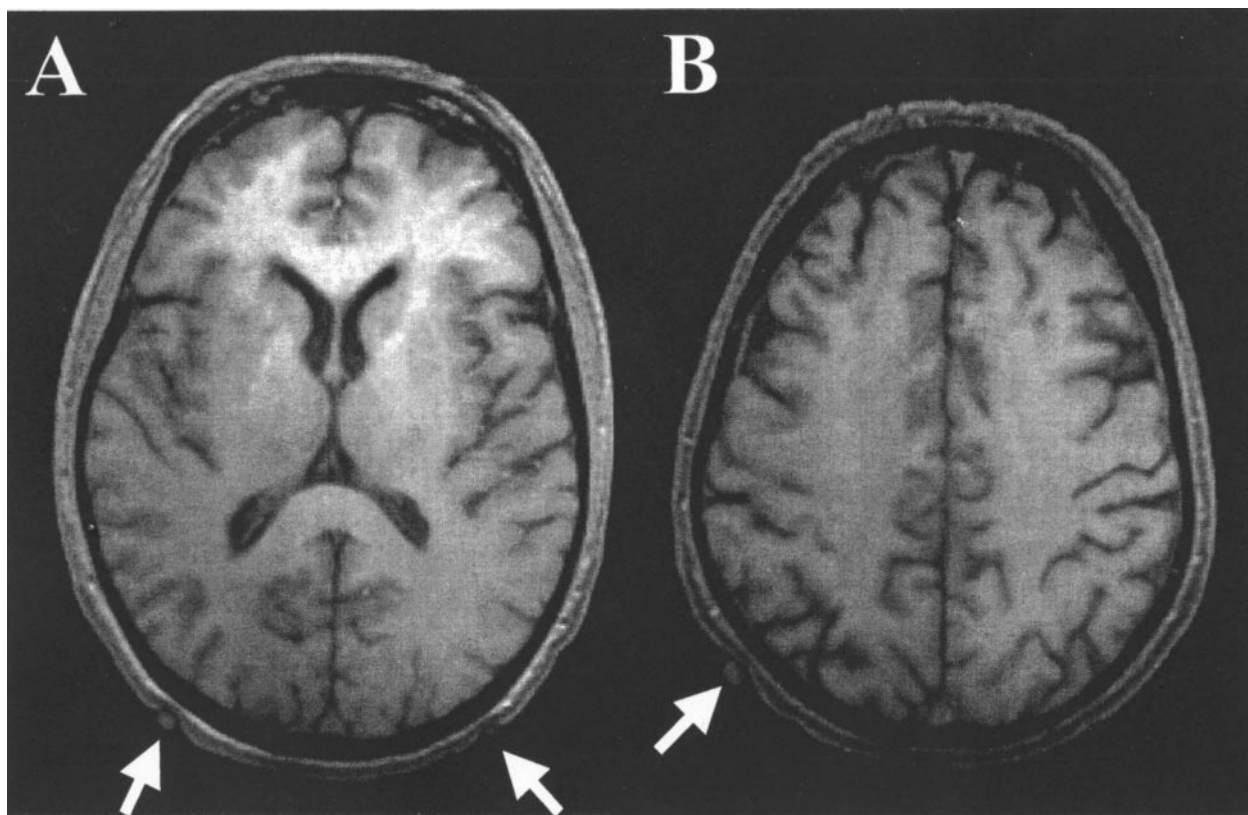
Structural images from one subject showing the location of the stimulation sites used for MT/V5 and posterior parietal (PPC) cortex. Images were T1-weighted (TR = 15 ms, TE = 6.9 ms, TI = 600 ms, flip angle = 12°, field of view = 256 (256 mm, matrix = 256 (256, 64 (3 mm slices with no gap between slices)). An oil capsule was placed over the regions stimulated. For MT/V5 the arrow on each side indicates the position of the ascending limb of the inferior temporal sulcus, which was traced over successive slices from its more ventral origin. It was much clearer on the right than left. The arrow on the right section indicates the right angular gyrus. TMS applied to the MT/V5 site shown here has consistently produced moving phosphenes, disrupted the motion after effect and disrupted motion discrimination in previous experiments. The PPC site shown here has also frequently been used in experiments in which TMS disrupts visuospatial processing.
